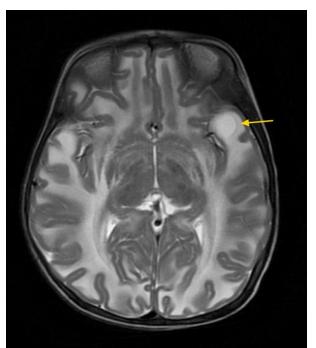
Axial T2 MRI showing same cyst (arrow) which is CSF intense.
